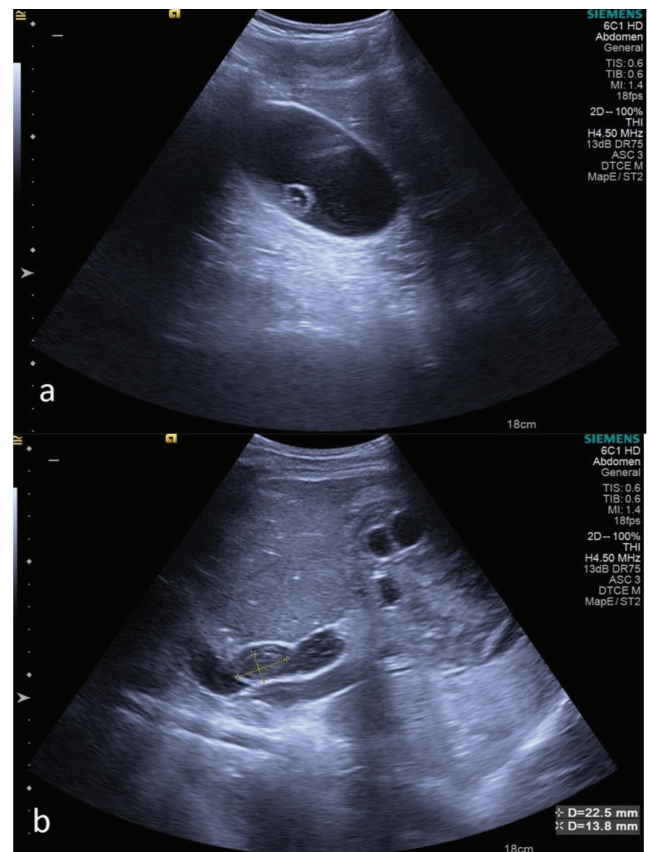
On the ultrasonographic examination, the gallbladder is distended and cholecystitis is observed. Image showing daughter vesicles in the gallbladder lumen (a) and common bile duct lumen (b)
